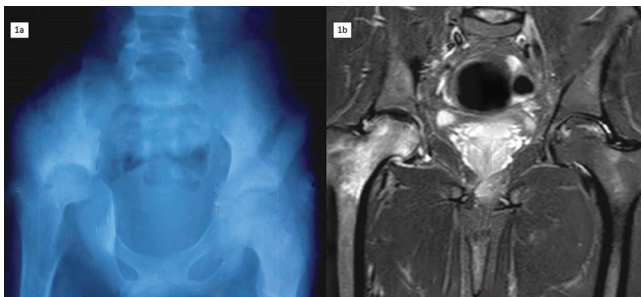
Case of bilateral AVN. AP radiograph of pelvic (1a) showing subchondral osteopenia with mild sclerosis in right femoral head with mild subchondral collapse. Left femoral head appears normal. Figure 1b (Coronal STIR MRI) image showing changes of bilateral AVN (Ficat stage III on right side and II on left side)
